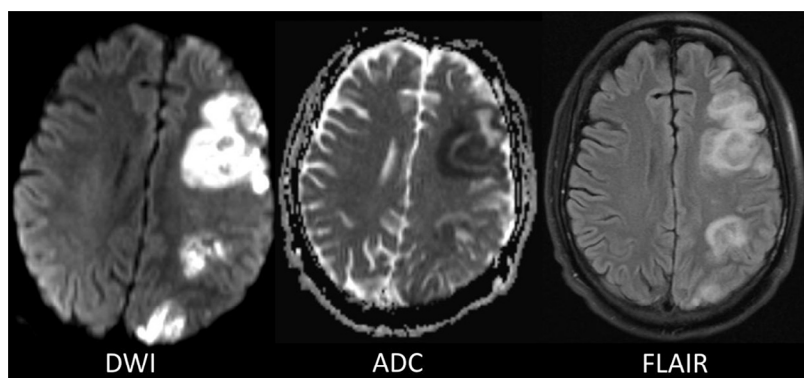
Left middle cerebral artery territory infarction. Magnetic resonance images of the brain demonstrate confluent and punctate areas of diffusion restriction within the territory of the left middle cerebral artery with associated FLAIR signal hyperintensity, consistent with acute infarction. Abbreviations: ADC, apparent diffusion coefficient; DWI, diffusion-weighted imaging; FLAIR, fluid-attenuated inversion recovery.
